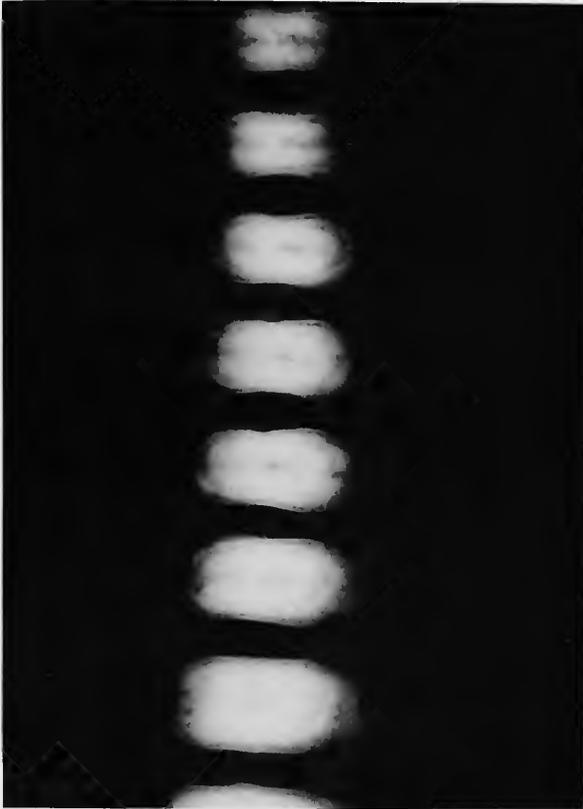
Osteopetrosis. X-ray of vertebral bodies. Notice the great density and concentric arrangement of bone. (15-month-old male, MGH autopsy 34143.)
